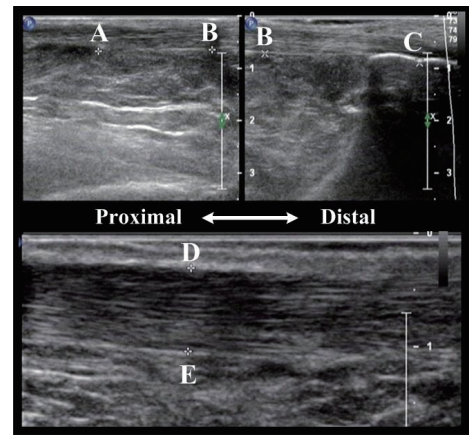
The Ultrasound image of AT. The length is the distance from the muscle-tendon junction (MTJ) (Point A) to the calcaneus notch (Point C). The thickness is the distance between the point D and the point E.
